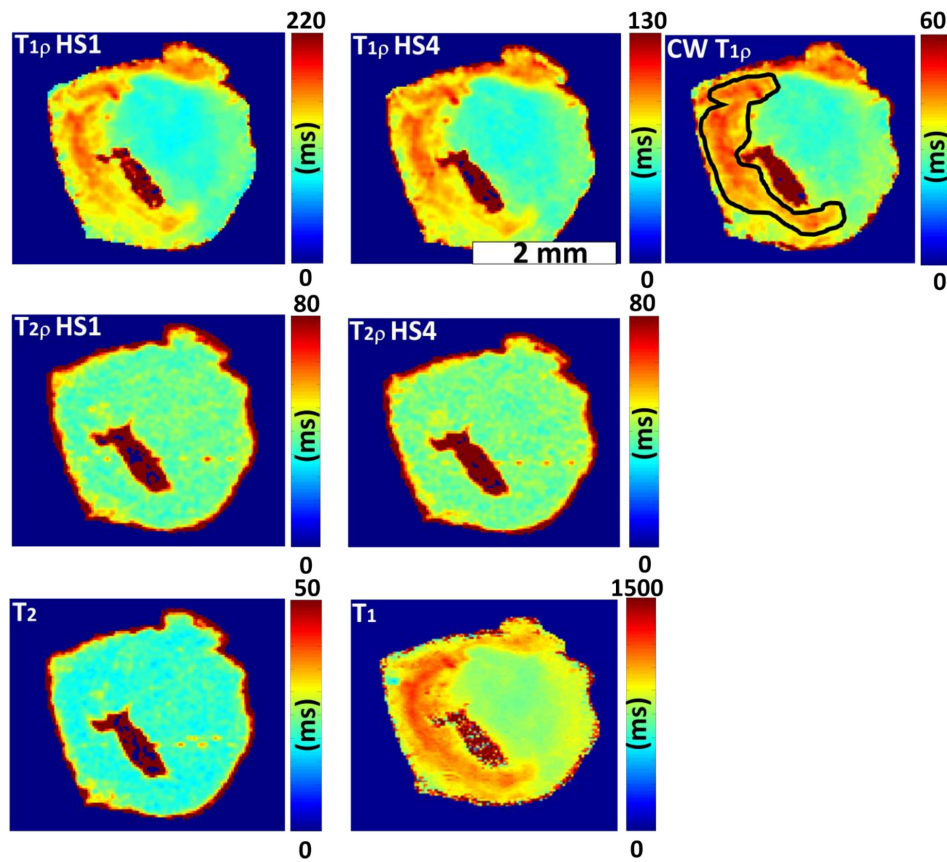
Representative ex vivo relaxation maps after 7 days of LAD occlusion with different rotating frames and conventional MRI methods. The outline of the selected ROI of infarct is presented with a black line in CW $T_{1\rho}$, and it was used in all relaxation time maps.
